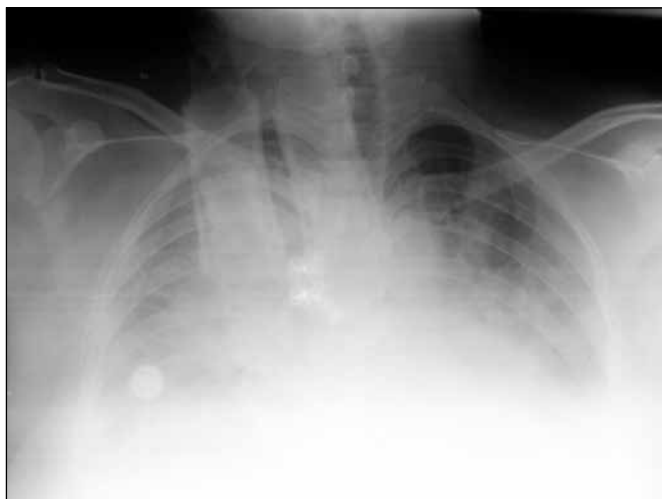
Chest X-ray at admission shows bilateral opacity in the lower and middle lung zones.
